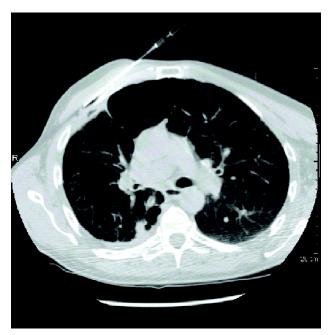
Extensive cavitary lesions of both upper lobes with soft-tissue density outlining right upper lobe cavities and CT-directed aspiration of right anterior dest wall air-fluid collection.
